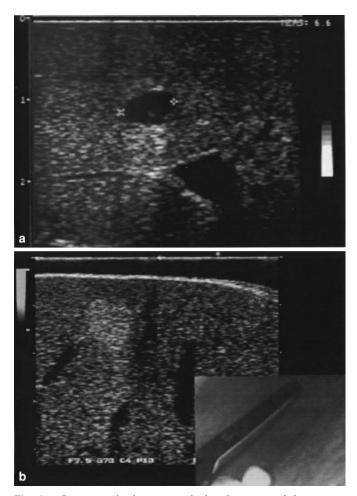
a. Laparoscopic ultrasonography has demonstrated that a potential metastatic deposit in the liver on CT scanning measures 6.6 mm in maximal diameter but has ultrasound features typical of a benign hepatic cyst. Note the posterior acoustic enhancement typical of a hepatic cyst. b. The transducer has been positioned in the right subphrenic space in a pool of instilled saline. The resultant ultrasound image demonstrates a hyperechoic lesion measuring approximately 1 cm in diameter lying just underneath the capsule of the liver. Ultrasound-guided biopsy confirmed the presence of an "occult" metastasis.
